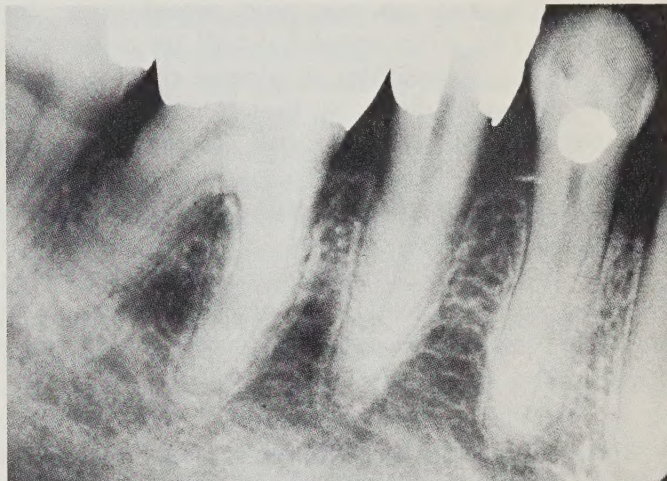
Radiograph of recipient site one year postoperatively. The presence of cortical alveolar crests, lamina dura, periodontal ligament spaces and normal pattern of trabeculae are suggestive of new attachment. A full gold crown has been placed on the mandibular right first molar and a MOD amalgam has been placed on the mandibular right second bicuspid.
